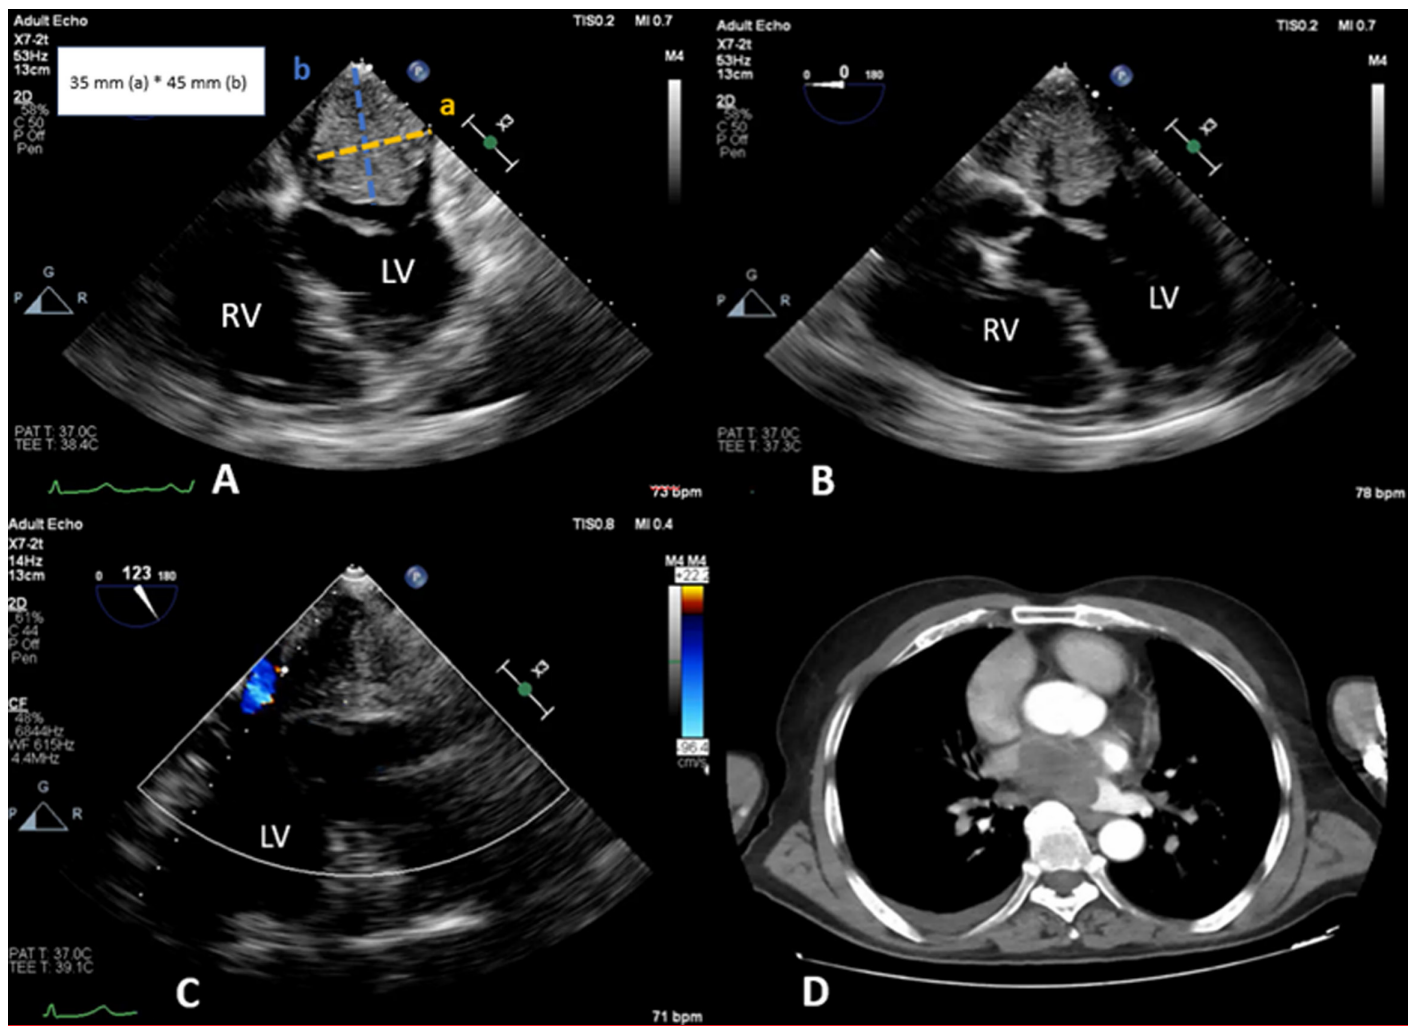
(A, B, C) Preoperative transesophageal echocardiography image demonstrating a cardiac mass. (D) Preoperative thoracic computed tomography image demonstrating a cardiac mass.
